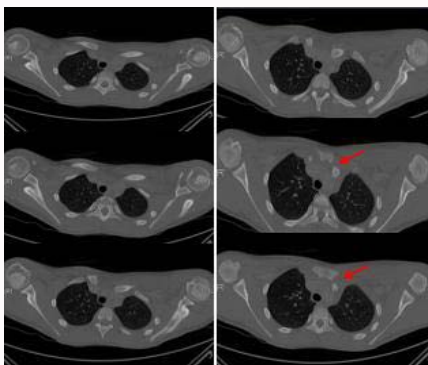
Axial views of CT scan. Images show posterior dislocation of clavicle.
